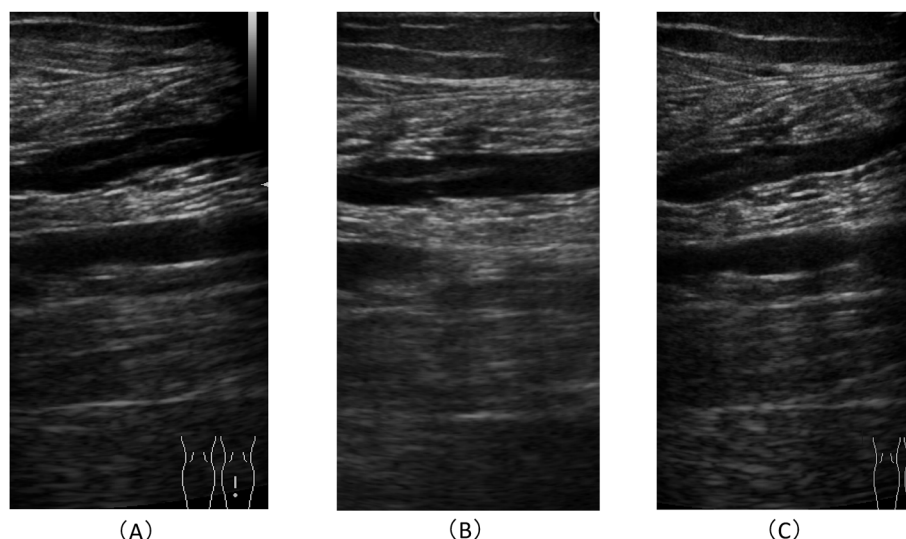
Duplex ultrasonography (DUS) showed thrombus with high echogenicity in the central soleal vein of a varicose vein patient with incompetent great saphenous veins (A). Serial examination with DUS revealed that the thrombus remained stable without any progression, 3 months after the first exam (B), and also in the postoperative period of the varicose vein surgery (C).
